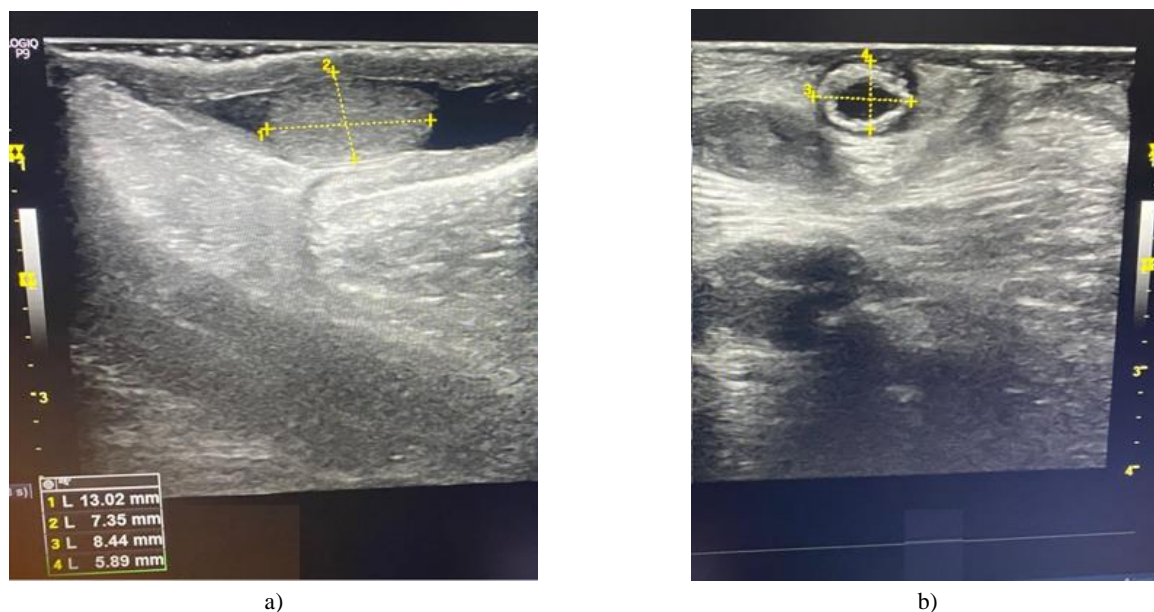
Measurement of testicular length, width, and height by ultrasound on a 17-year-old boy with Cryptorchidism with Testicular hypoplasia. The dotted line (1= 13.02 mm), (2= 7.35 mm), (3= 8.44 mm), and (4= 5.89 mm) show measurement of length and height in the longitudinal plane (a) and width in the transverse plain (b)
